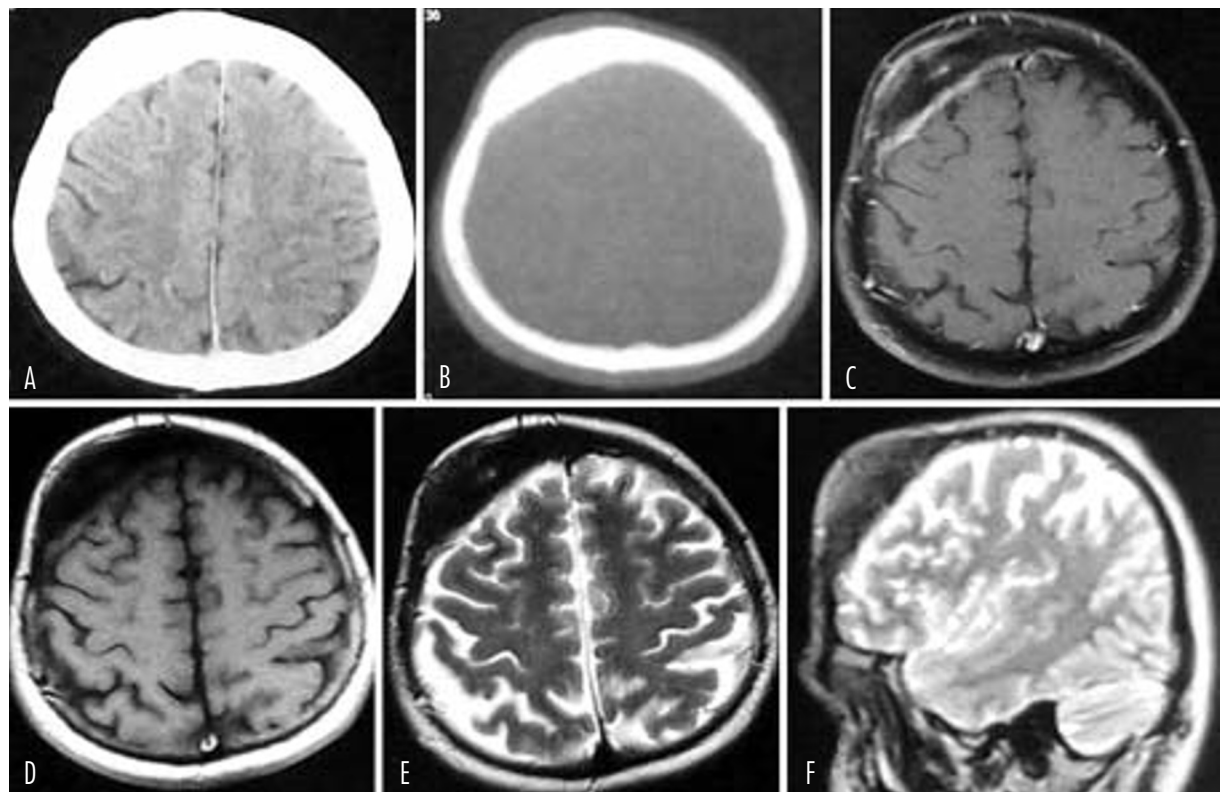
CT scan with bone window (A, B) demonstrates a right-sided frontal hyperostotic mass expanding the calvaria. Axial post-contrast T1-weighted (C), T1-weighted (D), T2-weighted (E) and sagittal T2-weighted (F) MR images show the hypointense right frontal intracalvarial mass lesion. After intravenous gadolinium infusion, contrast retention is observed at the bone lesion (C)
